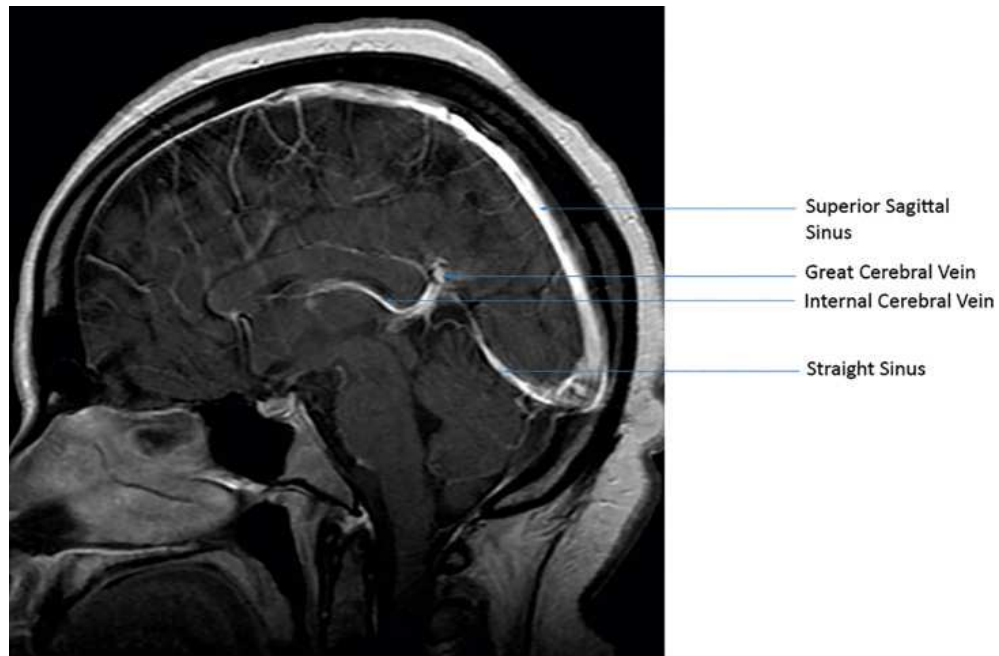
Midsagittal contrast-enhanced MR image of the brain.
